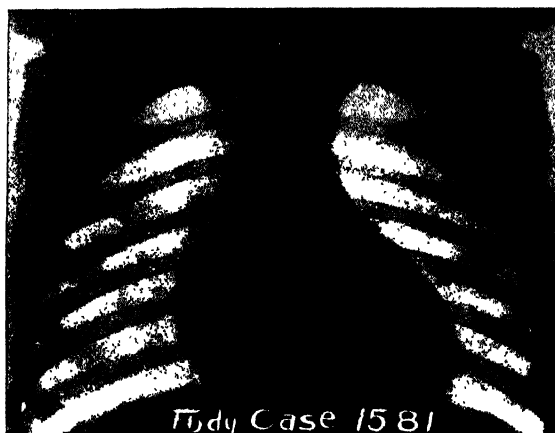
Typical example of many cases of overlooked foreign body as a cause of chronic lung suppuration: A girl, aged 4½ years, was supposed for a year and a half, by successive practitioners, to have asthma, asthmatic bronchitis, pulmonary abscess, and tuberculosis for which climatic treatment was advised. The mother insisted on the Roentgen-ray examination that revealed the staple, the bronchoscopic removal of which completely cured the patient. Film by Dr. Willis F. Manges. (Jour. Amer. Med. Assoc.)
